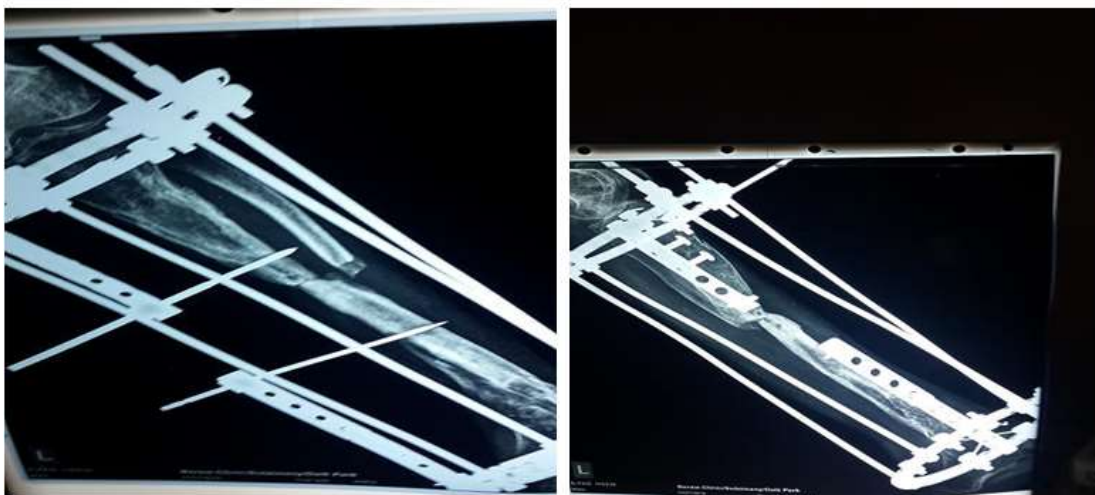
Plain radiograph A.P and lateral views, well corticalised distraction sites hypertrophied distal fragment of fibula.
